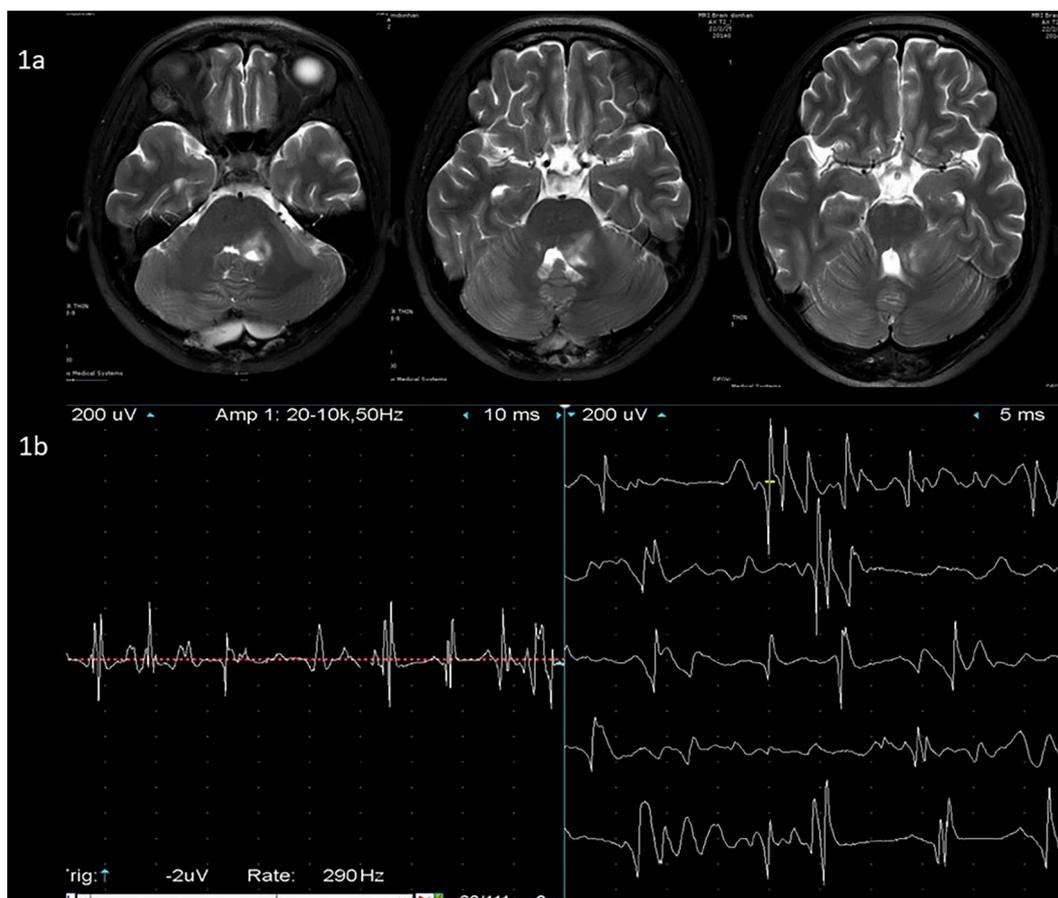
A: The brain MRI scan (T2-weight images) showed a 2*3 cm ill-defined hyperintensity lesion involving the left dorsal pons, left superior and middle cerebellar peduncles, and anterior aspect of left cerebellum; B: Concentric needle electromyography of left orbicularis oris muscle demonstrated brief bursts of doublets and triplets firing at irregular intervals ranging from 50 to 150 Hz.
